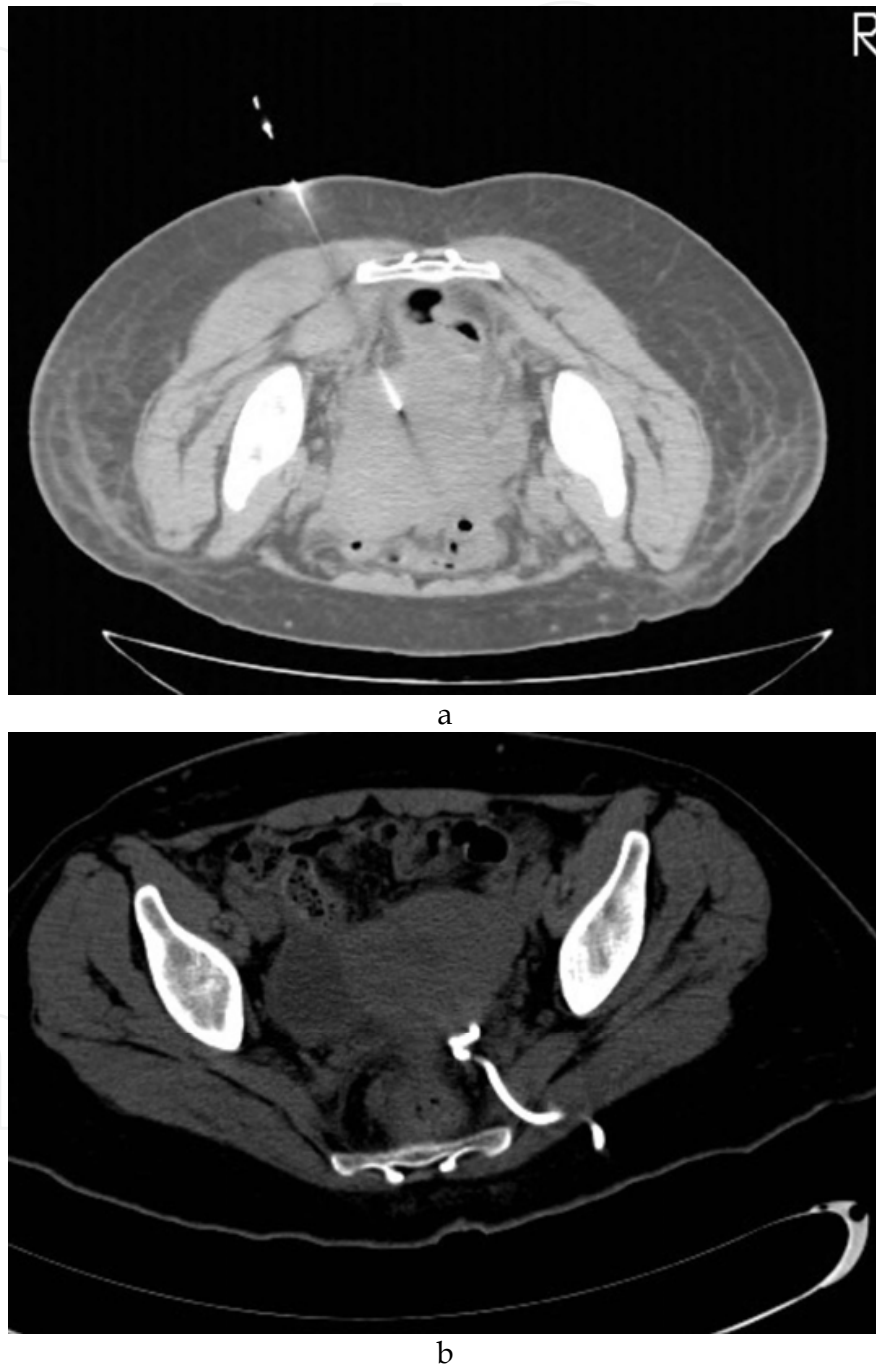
CT-guided percutaneous catheter drainage of a pelvic abscess secondary to a ruptured appendicitis. (a) CT-guidance for a percutaneous transgluteal approach needle and catheter insertion. (b) Follow-up MDCT image showing complete healing of the pelvic abscess. Patient underwent subsequent elective and interval appendectomy shortly afterward.
